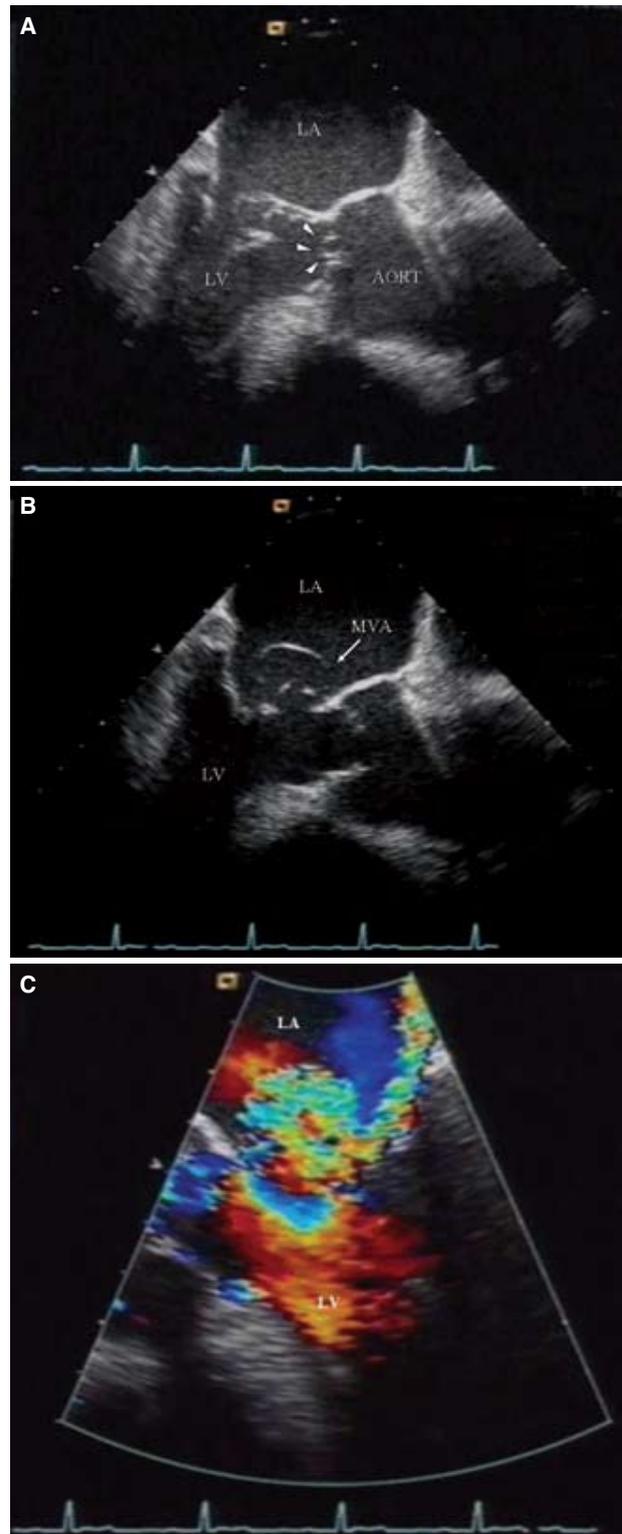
Transesophageal echocardiograms showing (A) aortic valve prolapsus (arrow heads) and (B) an aneurysm of the anterior mitral leaflet. (C) Color Doppler transesophageal echocardiogram showing regurgitant aortic insufficiency jet striking the anterior mitral valve leaflet. (LA: Left atrium; LV: Left ventricle; MVA: Mitral valve aneurysm)
